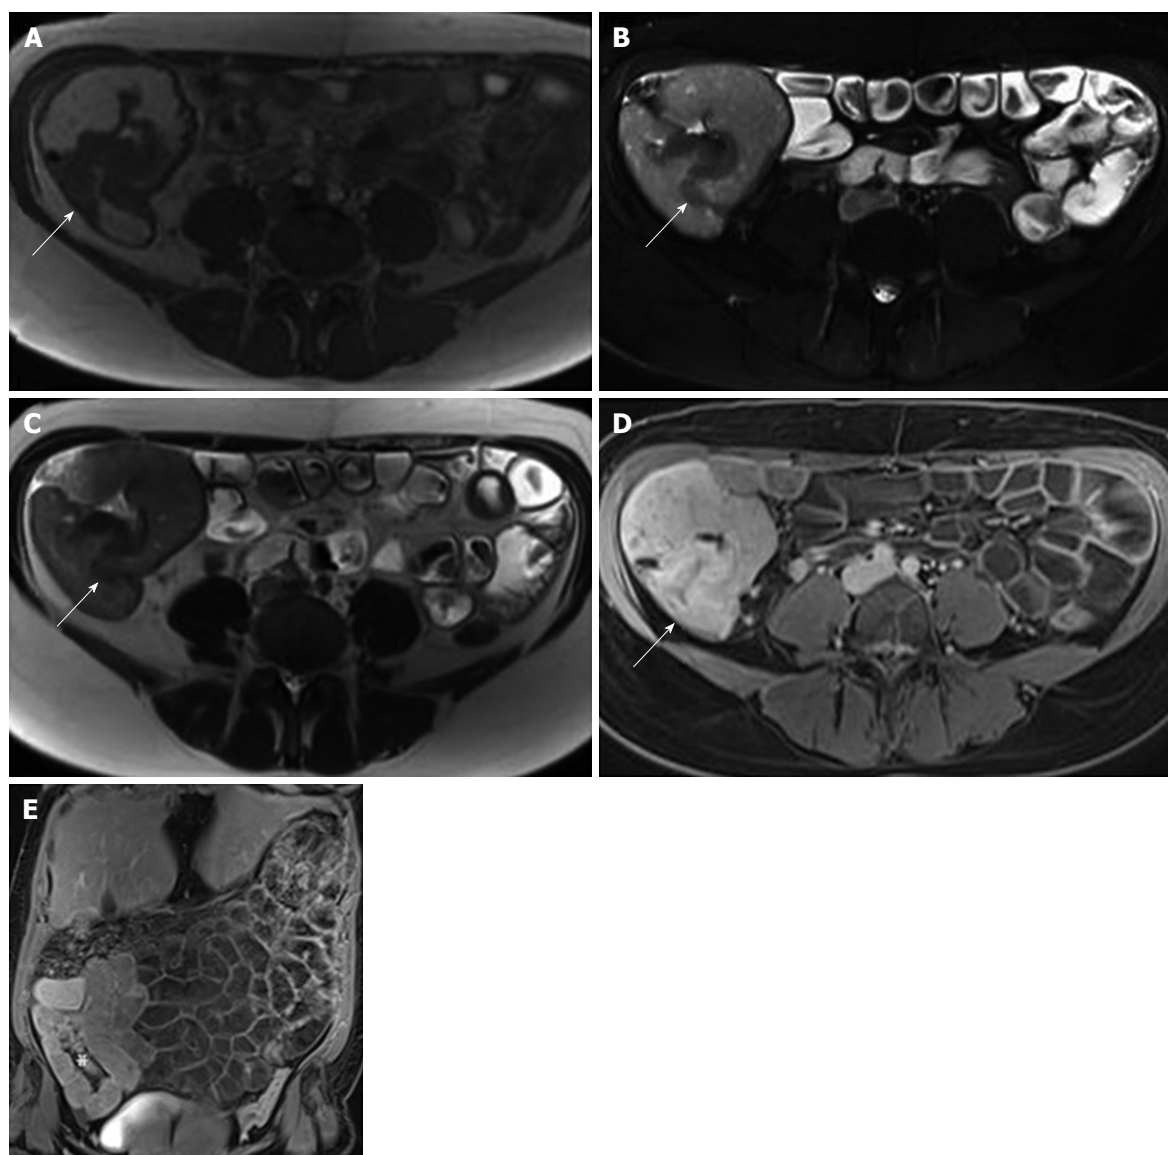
Magnetic resonance imaging showed mural thickening of the ileocecum and the appendix, which was interpreted as being inflammatory in nature. A-E: Magnetic resonance images (A: T2-weighted magnetization transfer contrast transversal; B: T2-weighted fat saturated transversal; C: T2-weighted half-Fourier acquired single-shot turbo spin-echo transversal; D: T1-weighted VIBE-Dixon postcontrast transversal, E: T1-weighted VIBE-Dixon postcontrast coronal) showing mural thickening (arrows in A-C) of the ileocecum and the appendix with contrast enhancement (arrow in D, asterisk in E).
